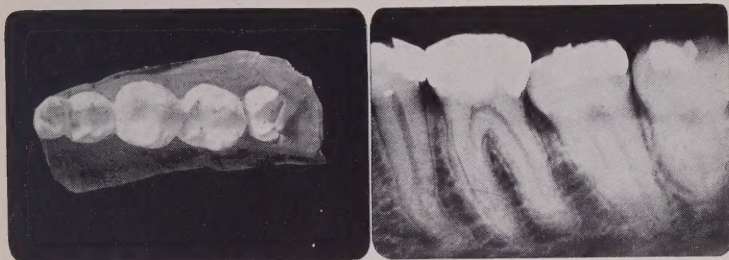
MODEL AND RADIOGRAPH OF PARTLY ERUPTED LOWER RIGHT THIRD MOLAR
